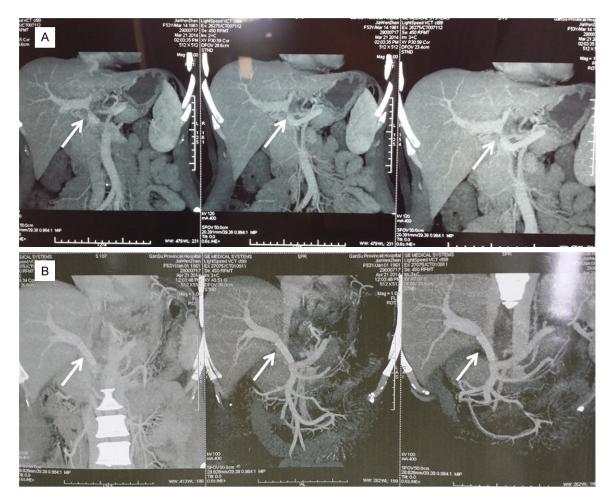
A advanced HCCA patient with portal vein invasion underwent combined portal vein resection and reconstruction with vascular graft. Preoperative MRI examination (A) showed the type IIIB lesion with contralateral portal vein invasion. One month later, postoperative MRI examination (B) presented that the invaded portal vein was resected and reconstructed vessel with vascular graft kept patent.
